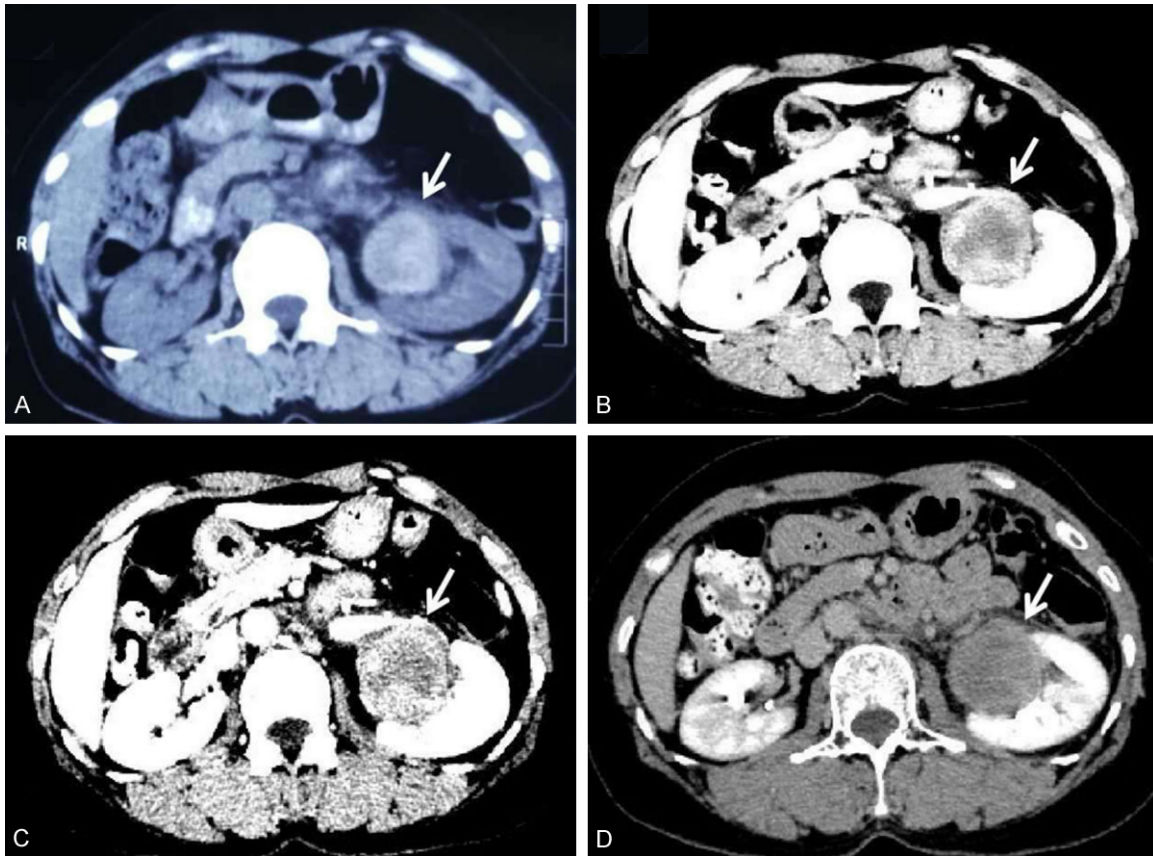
A. The CT scan. 4.2×4.5 cm soft tissue density mass was closely related to the left renal pelvis with some slight high-density shading. B. The arterial phase of CT scan. The mass had some slight reinforcement in the arterial phase. C. The venous phase of CT scan. The mass had an uneven reinforcement in the venous phase. D. The secretory phase of CT scan. The uneven reinforcement of the mass mildly reduced.
